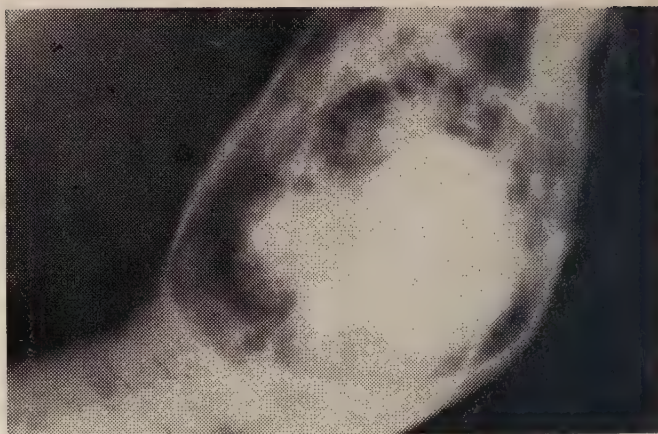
La radiographie occlusale montre la dent incluse située au centre de la lésion.
